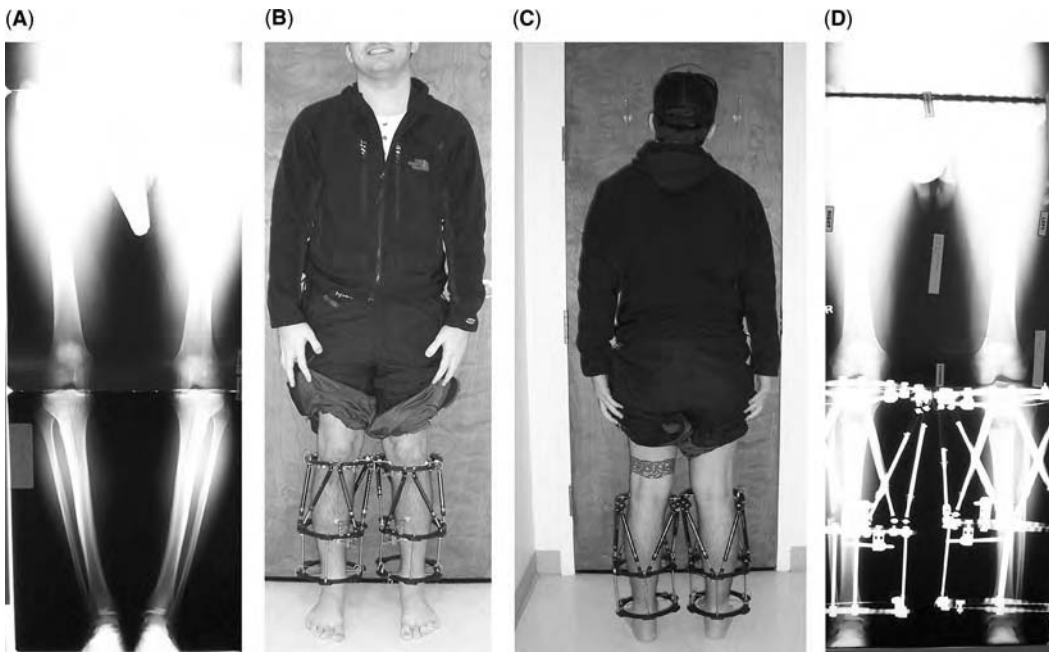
Case example of 1" lengthening and correction of bilateral genu varum using the Ilizarov/Taylor spatial frames. (A) Preoperative 51" radiograph showing bilateral genu varum. (B–D) At the end of distraction, showing correction of deformity and 1" lengthening. (E) Anteroposterior radiograph four months after surgery of the right side showing progression of healing. (F) Clinical view at five months after distal rings have been removed for dynamization and to improve mobility. (G) Clinical view at six months showing a staged removal of three weeks between sides. (H and I) Front and side views one month after removal (seven months after initial surgery). (J) Standing 51" radiograph four months after removal showing correction of deformity and 1" lengthening.
